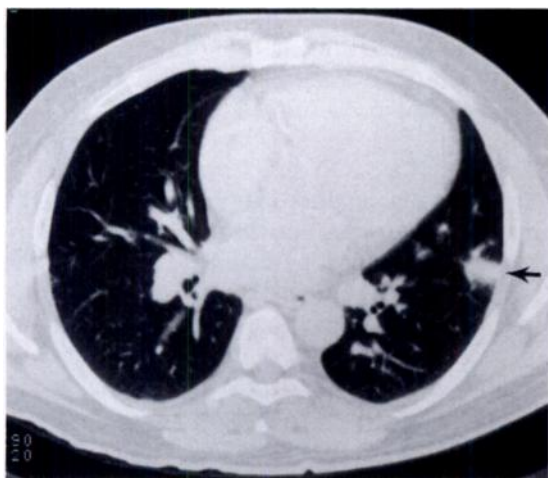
Septic pulmonary emboli. CT scan demonstrates an ill-defined area of high attenuation in the periphery, which is believed to represent a septic embolus (arrow).
